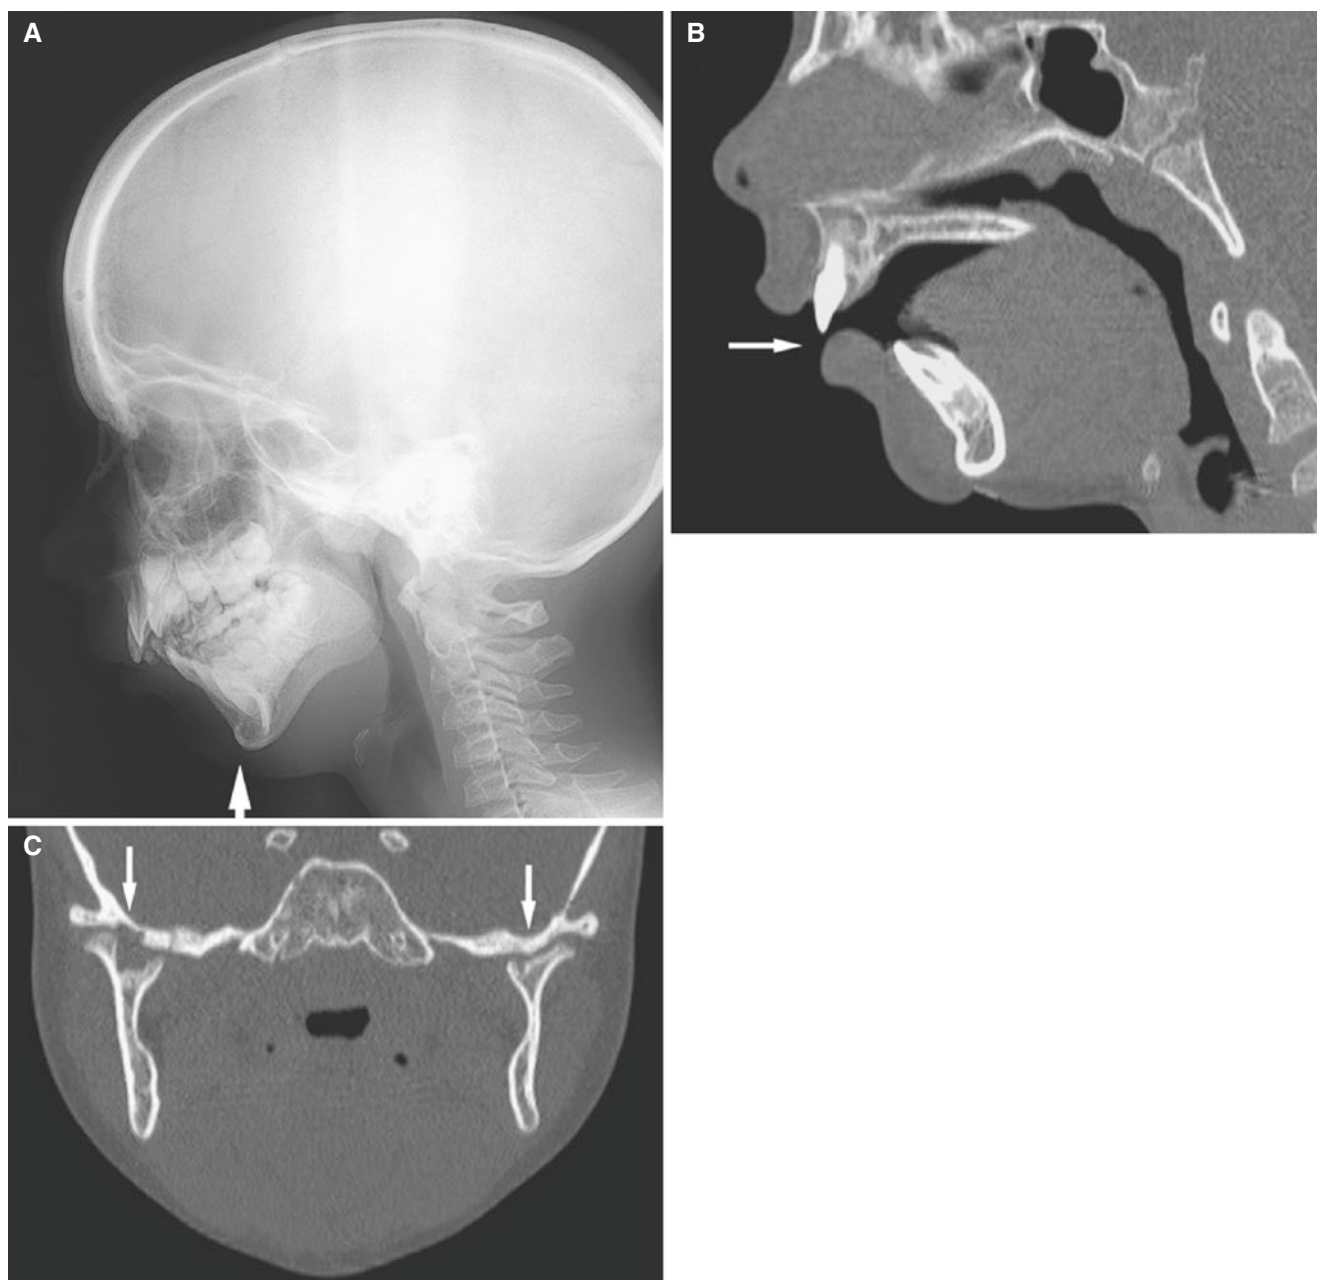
Mandibular underdevelopment; 7-year-old male with history of septic arthritis at birth with subsequent osteomyelitis and surgery of hips, now with gradually inhibited mandibular growth and mouth-opening capacity (27 mm). (A) Lateral view shows mandibular retrognathia (arrow) with some asymmetry. (B) Sagittal CT image shows severe dental malocclusion (arrow). (C) Coronal CT image shows bilaterally deformed TMJs but no ankyloses (arrows)
